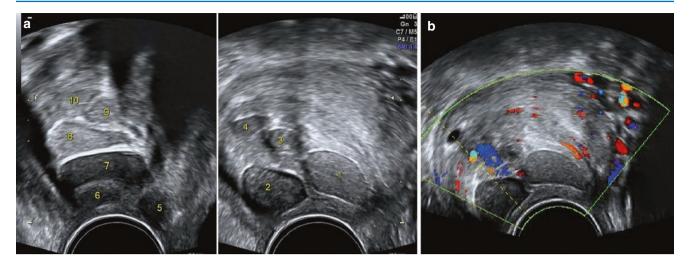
Cervix with multiple (more than 10) nabothian cysts. (a) Nabothian cysts showing turbid contents. (b) Doppler evaluation done to help with differential diagnosis. *HPE:* chronic cervicitis
